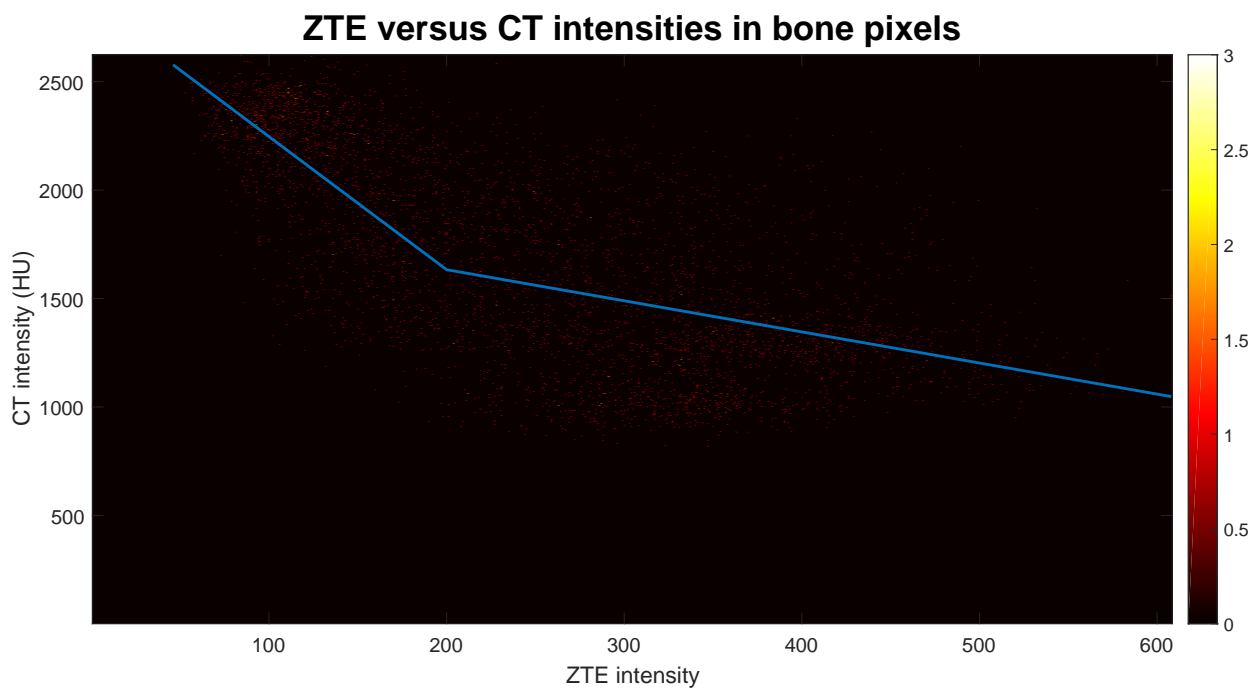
A continuous two-segment piecewise linear model is fitted to the joint histogram of the ZTE and the CT bone intensities.
